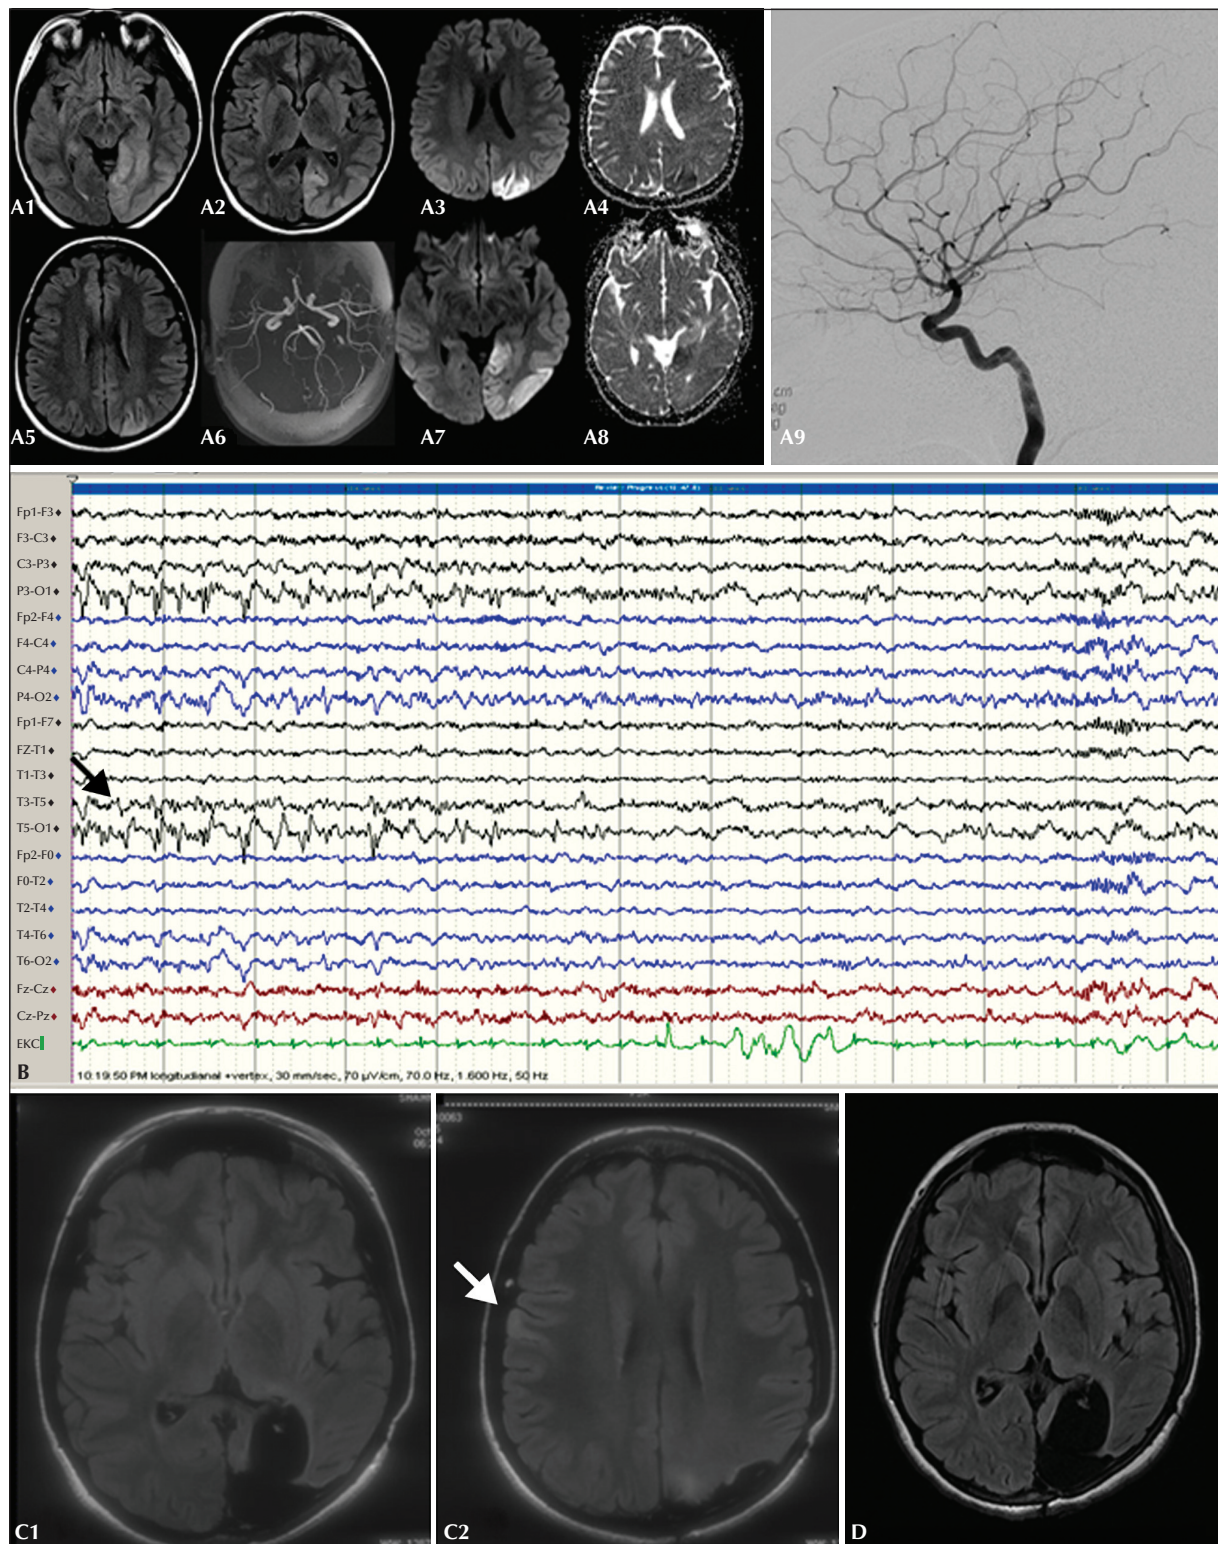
(A) Pre-operative MRI from November 2014 showing FLAIR hyperintensities over the left parietal and entire left occipital region (A1, A2, A5) with diffusion restriction over the left parietal cortex (A3-A4) and left medial parieto-occipital junction (A7-A8), with normal TOF MR angiogram (A6) and digital subtraction angiogram (A9). (B) Ictal EEG showing a focal ictal rhythm over the left posterior cortex (arrow) (bipolar montage; sensitivity: 7 μ V/mm; low-pass filter: 50 Hz; high-pass filter: 1.6 Hz; notch filter: 50 Hz). (C) Post-operative FLAIR image showing scar of the left occipital lobectomy (C1) and new hyperintensity over the right frontal region (C2; May 2015). (D) Scar of left occipital lobectomy in MRI performed in February 2016 following treatment with steroids and rituximab showing disappearance of right frontal hyperintensity.
